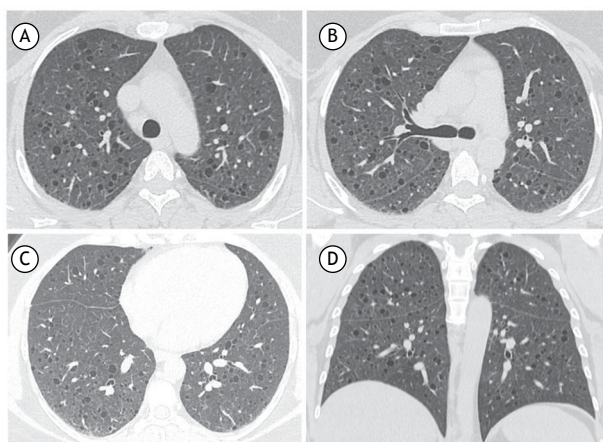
HRCT showing multiple bilateral, diffuse, thin-walled pulmonary cysts accompanied by widespread ground-glass opacities.
